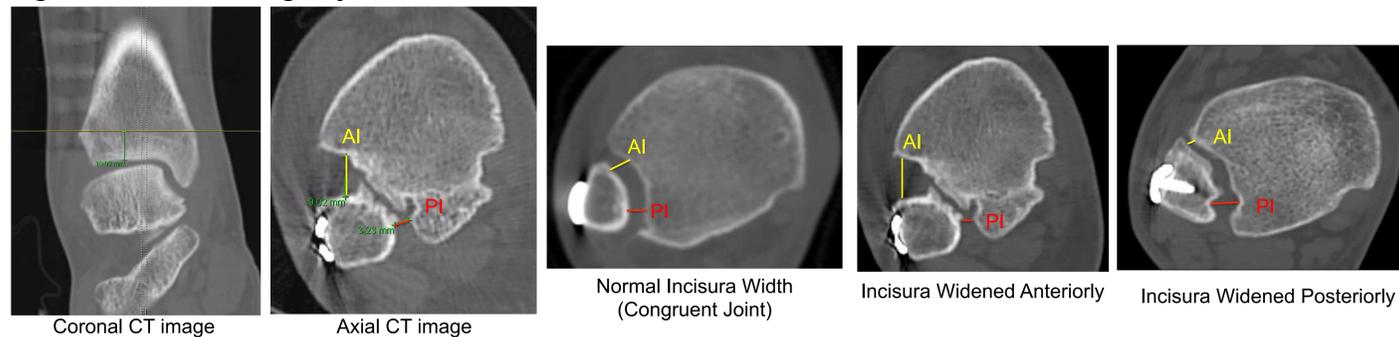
Fibular Incongruity Within the Incisura as Measured on Axial CT
